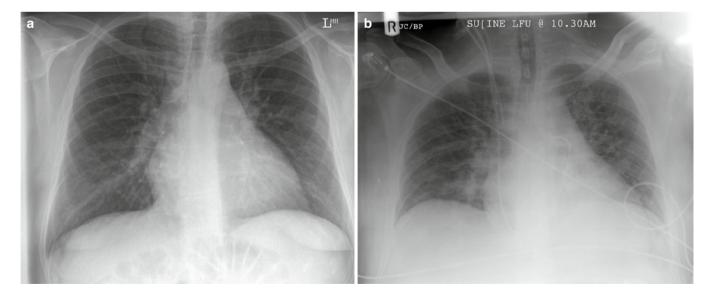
(a) Pre-orthotopic liver transplantation (OLT) chest X-ray reported as normal in a man with end stage cirrhosis. There is pulmonary artery enlargement, indicating probable porto-pulmonary hypertension. (b) By 48 h post-OLT the patient was hypoxic and vasopressor- and inotrope-dependent. Pulmonary artery pressures via the Swan–Ganz catheter were 74/29 mmHg, and despite aggressive treatment with nebulized prostacyclin, bosentan, and sildenafil he succumbed due to cardiac failure 8 days later.
